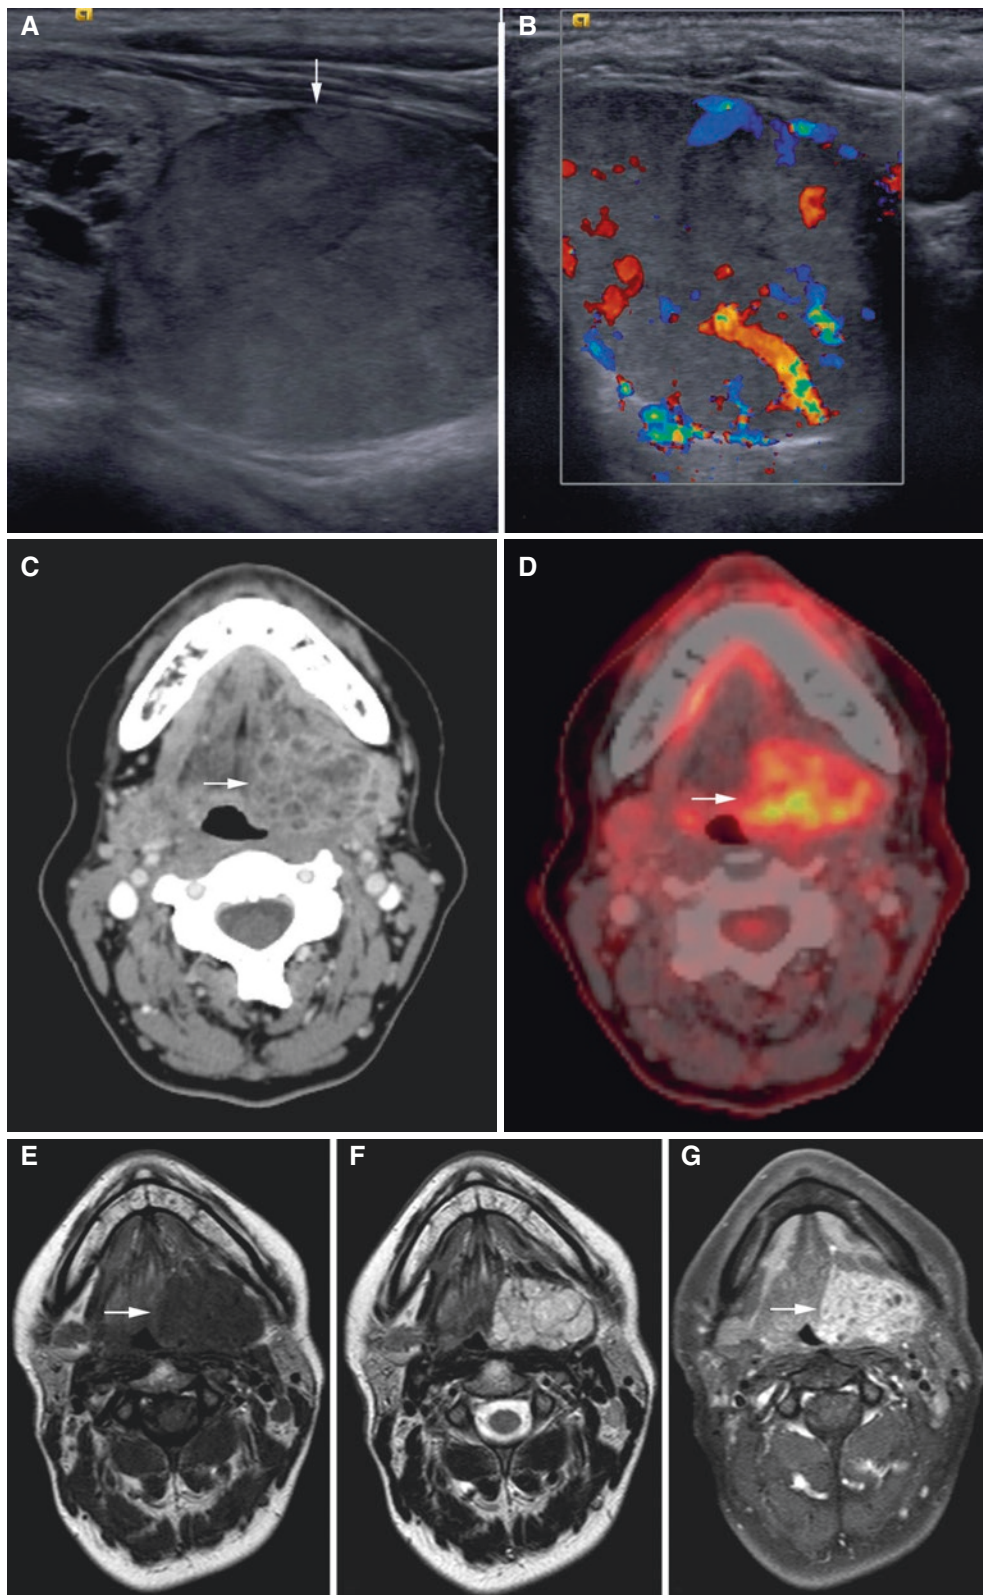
Submandibular gland adenoid cystic carcinoma: 46-year-old female with swelling in the floor of the mouth. (A) US and (B) US (Doppler) images show encapsulated mass (*arrow*) with increased vascularity and mildly heterogeneous echogenicity. (C) Axial contrast-enhanced CT image shows avid enhancement with multicystic pattern within mass (*arrow*). (D) Axial PET-CT shows avid, heterogeneous
